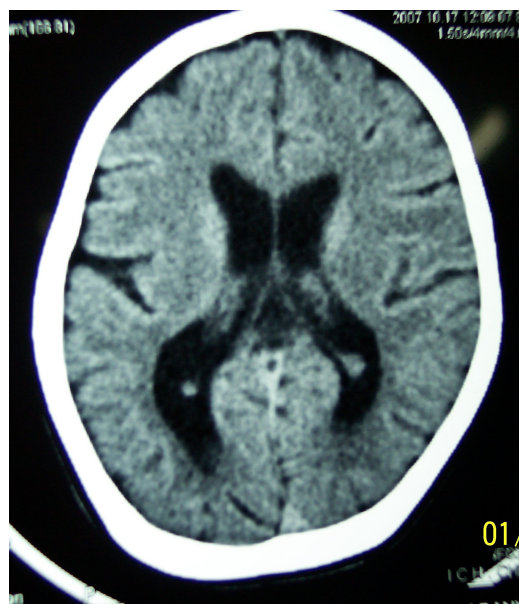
CT picture showing diffuse cerebral atrophy with passive dilatation of ventricles.
